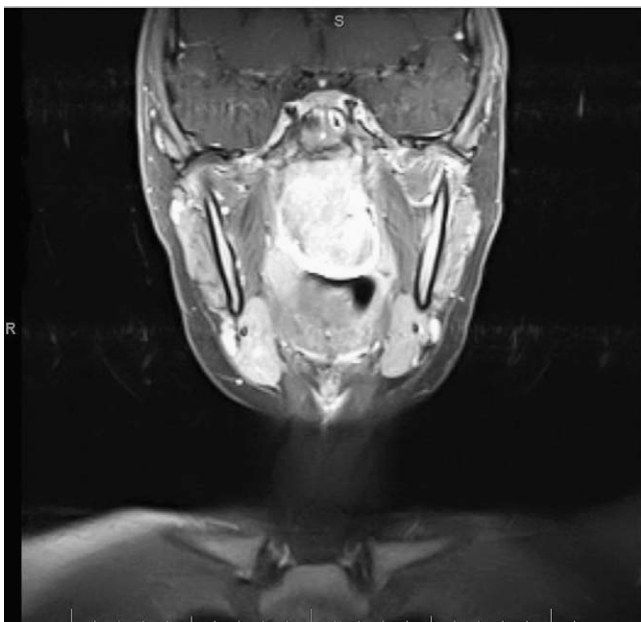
MRI of a Radkowski Stage IIB juvenile nasopharyngeal angiofibroma.
